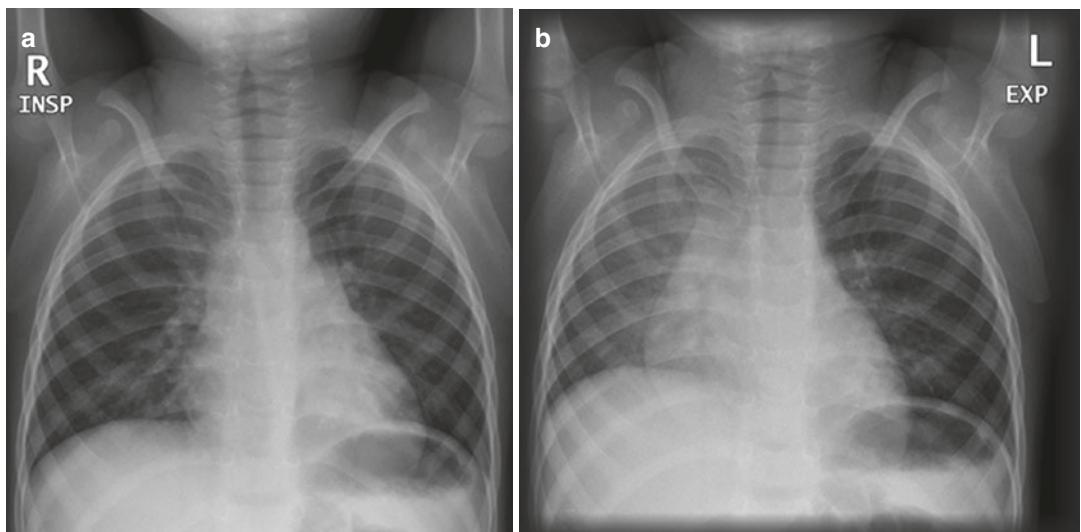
(a) Inspiratory and (b) expiratory PA chest radiographs in a 4-year-old boy with foreign body aspiration. Air trapping with increased lucency on the left is
